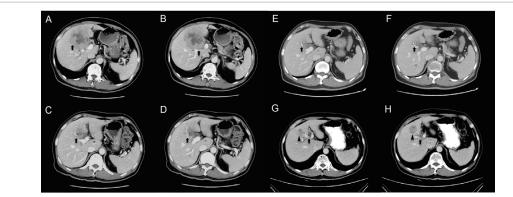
A, B (baseline CT scan): A thick-walled gallbladder with local infiltration to the adjacent liver (arrow); C, D (after 2 cycles of chemotherapy): gallbladder lesion diminished (arrow); E, F (after 4 cycles of chemotherapy): gallbladder lesion was stable (arrow); G, H: gallbladder lesion enlarged (arrow) and a mass in the fifth segment (arrowhead) appeared.
